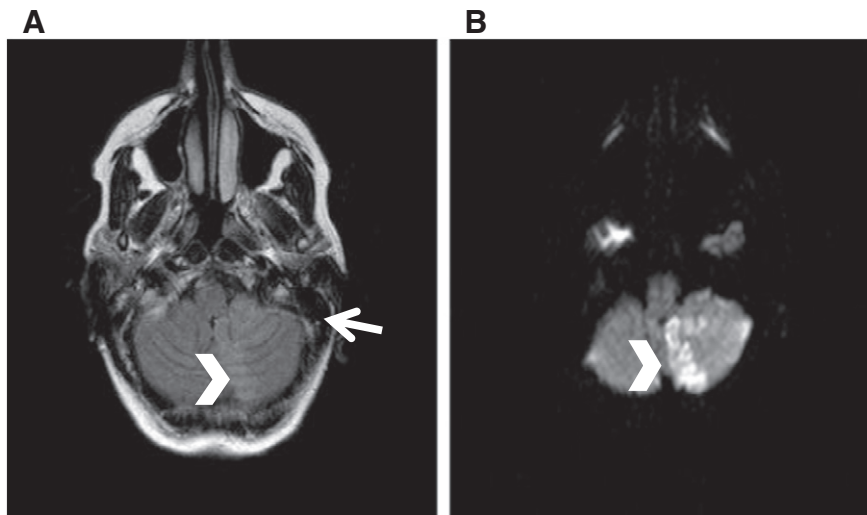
A. Axial FLAIR image demonstrates abnormal signal intensity (arrowhead), representing subacute infarction in the distribution of the left posterior inferior cerebellar artery, in the medial inferior left cerebellum extending to the cerebellar tonsil. There is a suggestion of wall thickening/intramural hematoma (arrow) within the distal left vertebral artery. B. Axial diffusion weighted image demonstrates hyperintensity (arrowhead) in the same region.
